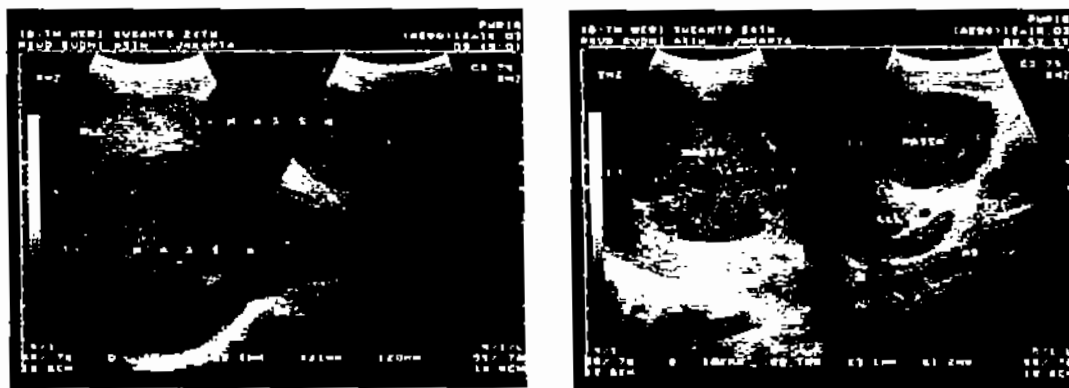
Abdominal ultrasound showed hepatomegaly with multiple lesions, blood vessels and biliary tract are deviated
